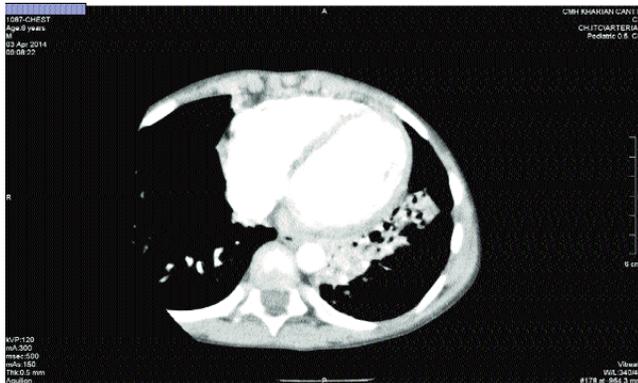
Plain CT scan of the child showing a classical patch of consolidation in left lower lobe with air bronchograms.
